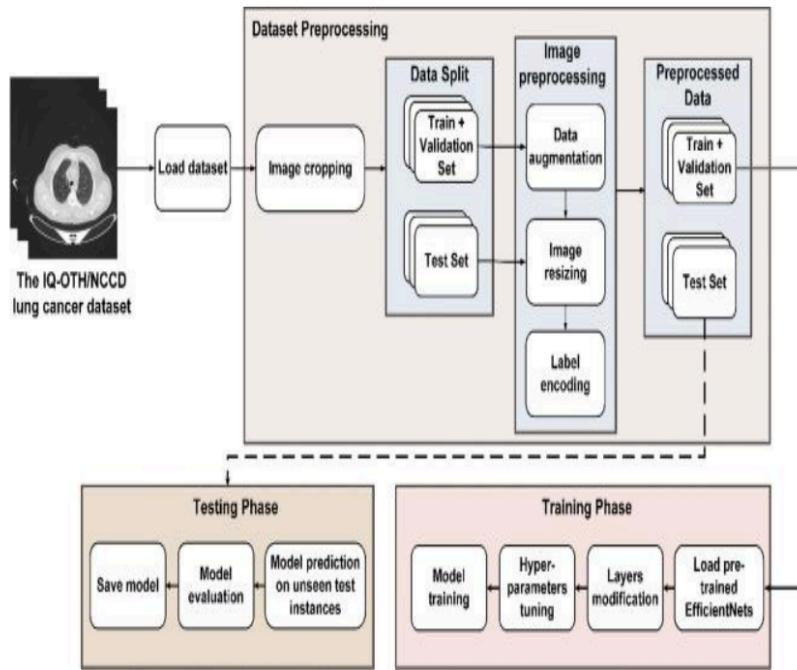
Lung-EffNet : Lung cancer classification using EfficientNet from CT-scan images
